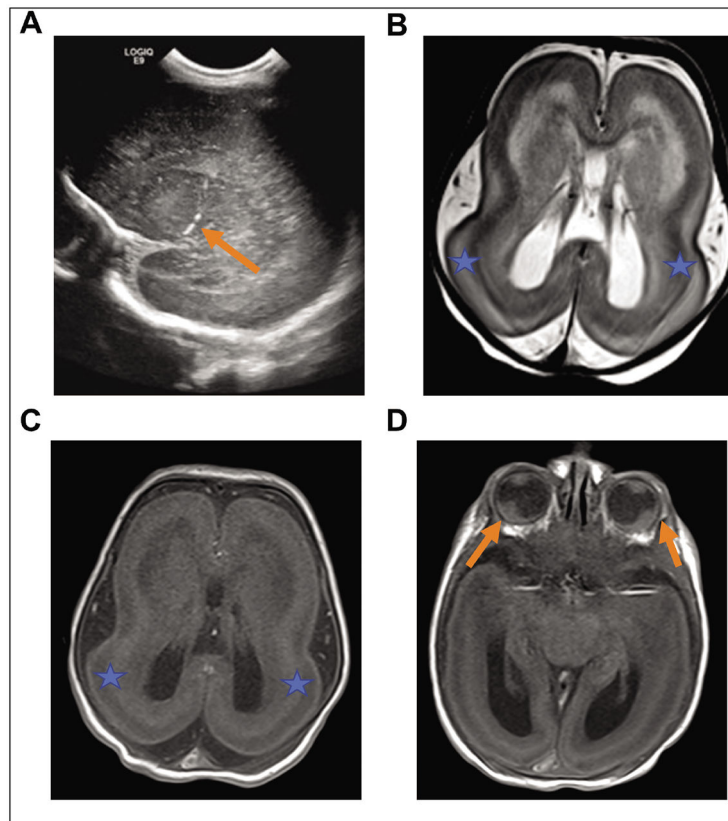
Neuroradiographic anomalies. (A) Left sagittal head ultrasound demonstrating nonspecific lenticulostriate vasculopathy (arrow). (B) Axial T1-weighted and (C) T2-weighted MRI of brain show lissencephaly, a few shallow sulci, (B and C) shallow Sylvian fissures with hourglass appearance and subcortical band heterotopia (stars). (D) Retinal detachments bilaterally also noted (arrows).
